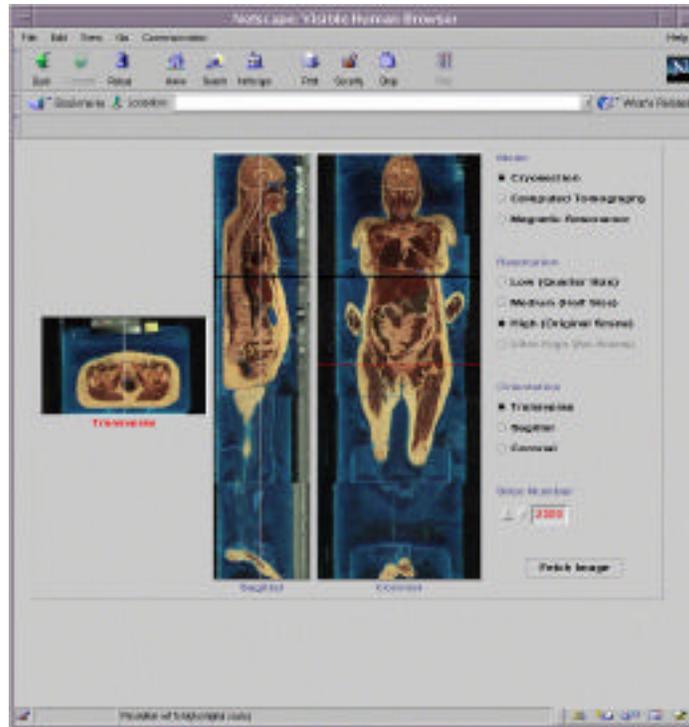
Main window for the version 2.0 UM Visible Human browser. From this page, one chooses image mode (cryosection, CT, or MRI), resolution (low, medium, or high), orientation (transverse, coronal, or sagittal), and slice number. Images are delivered via the WWW.
